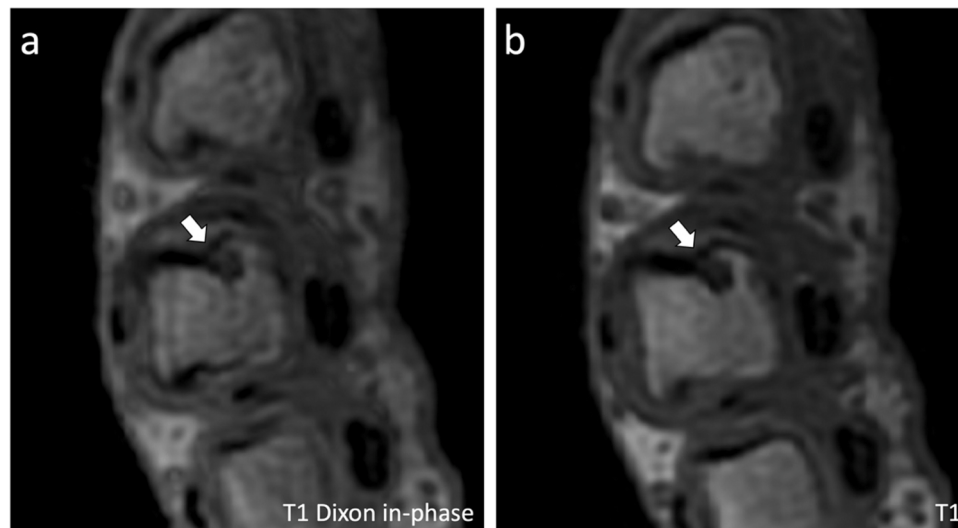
Similar appearance of metacarpal head erosion (white arrows) on axial 3D GRE T1-weighted (a) Dixon in-phase and (b) non-Dixon focused images in a 60-year-old man with early RA.
